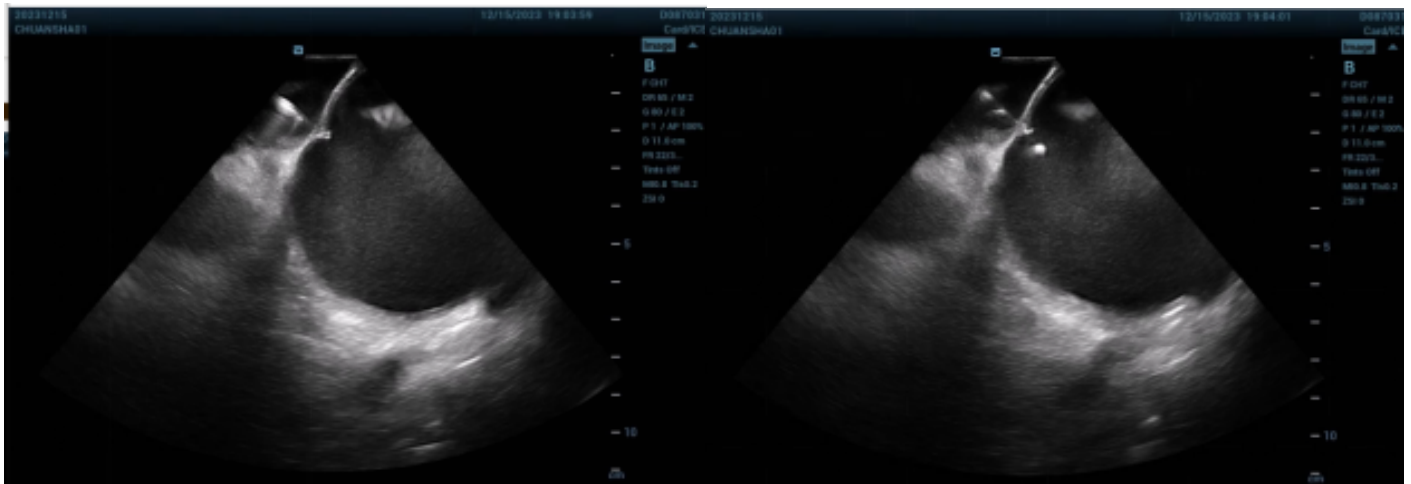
Images taken during the intracardiac echocardiography-guided transseptal puncture. A) Septal tenting caused by the needle tip, B) Image of the needle tip penetrating the septum into the left atrium.
